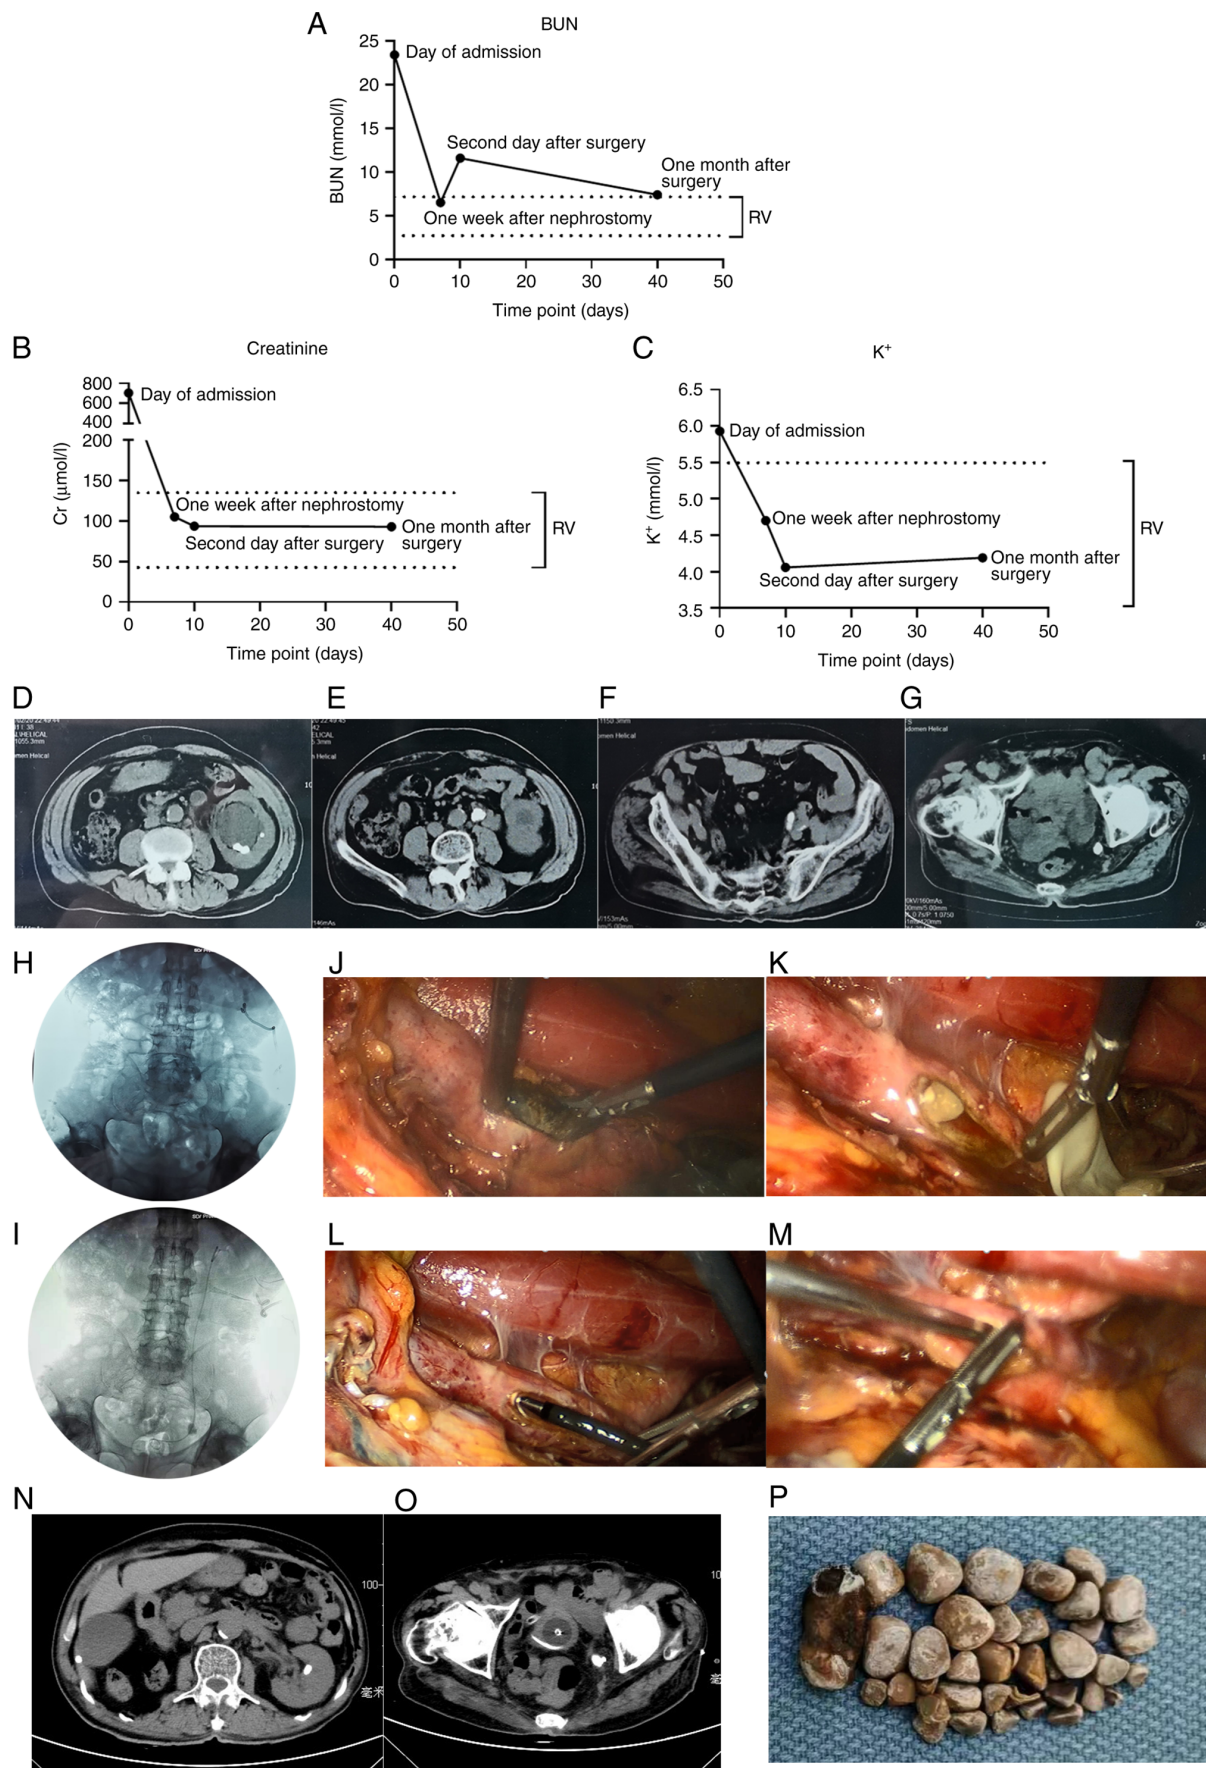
Laparoscopy and ureteroscopy cooperative surgery in solitary kidney and ureter stones. (A-C) Renal function and changes in blood biochemistry for the whole procedure. (D-G) CT before admission of the patient. (H, I) The kidney, ureter and bladder (H) before and (I) after surgery. The key procedures in the surgery are shown: (J) the step of laparoscopic ureterolithotomy; (K) calculi were washed out through the renal fistula; (L) the step of flexible ureteroscopy exploratory surgery; and (M) the steps of rigid ureteroscopy lithotripsy and pneumatic lithotripsy. (N, O) CT following the surgery. (P) Image captured of the stones removed from the patient. BUN, blood urea nitrogen; Cr, creatinine; CT, computed tomography.
